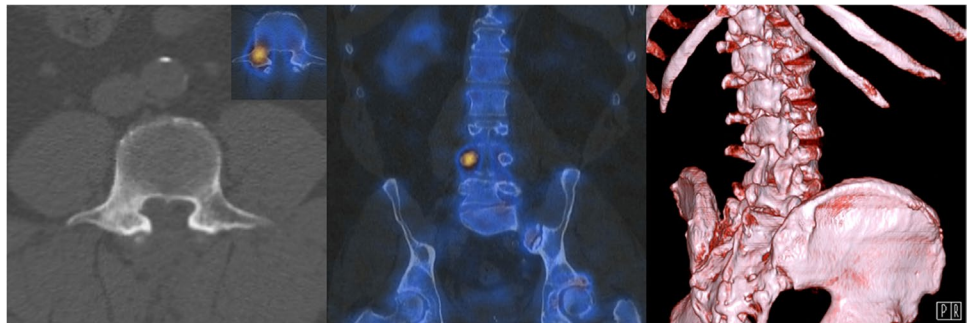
Left: axial CT-view of the L4 vertebra shows a sclerotic right pedicle. Middle: coronal SPECT-CT view showing a markedly increased osteogenesis. Right: volume-rendered image demonstrating the laminectomy with the right L4-pedicle at the center of the image
